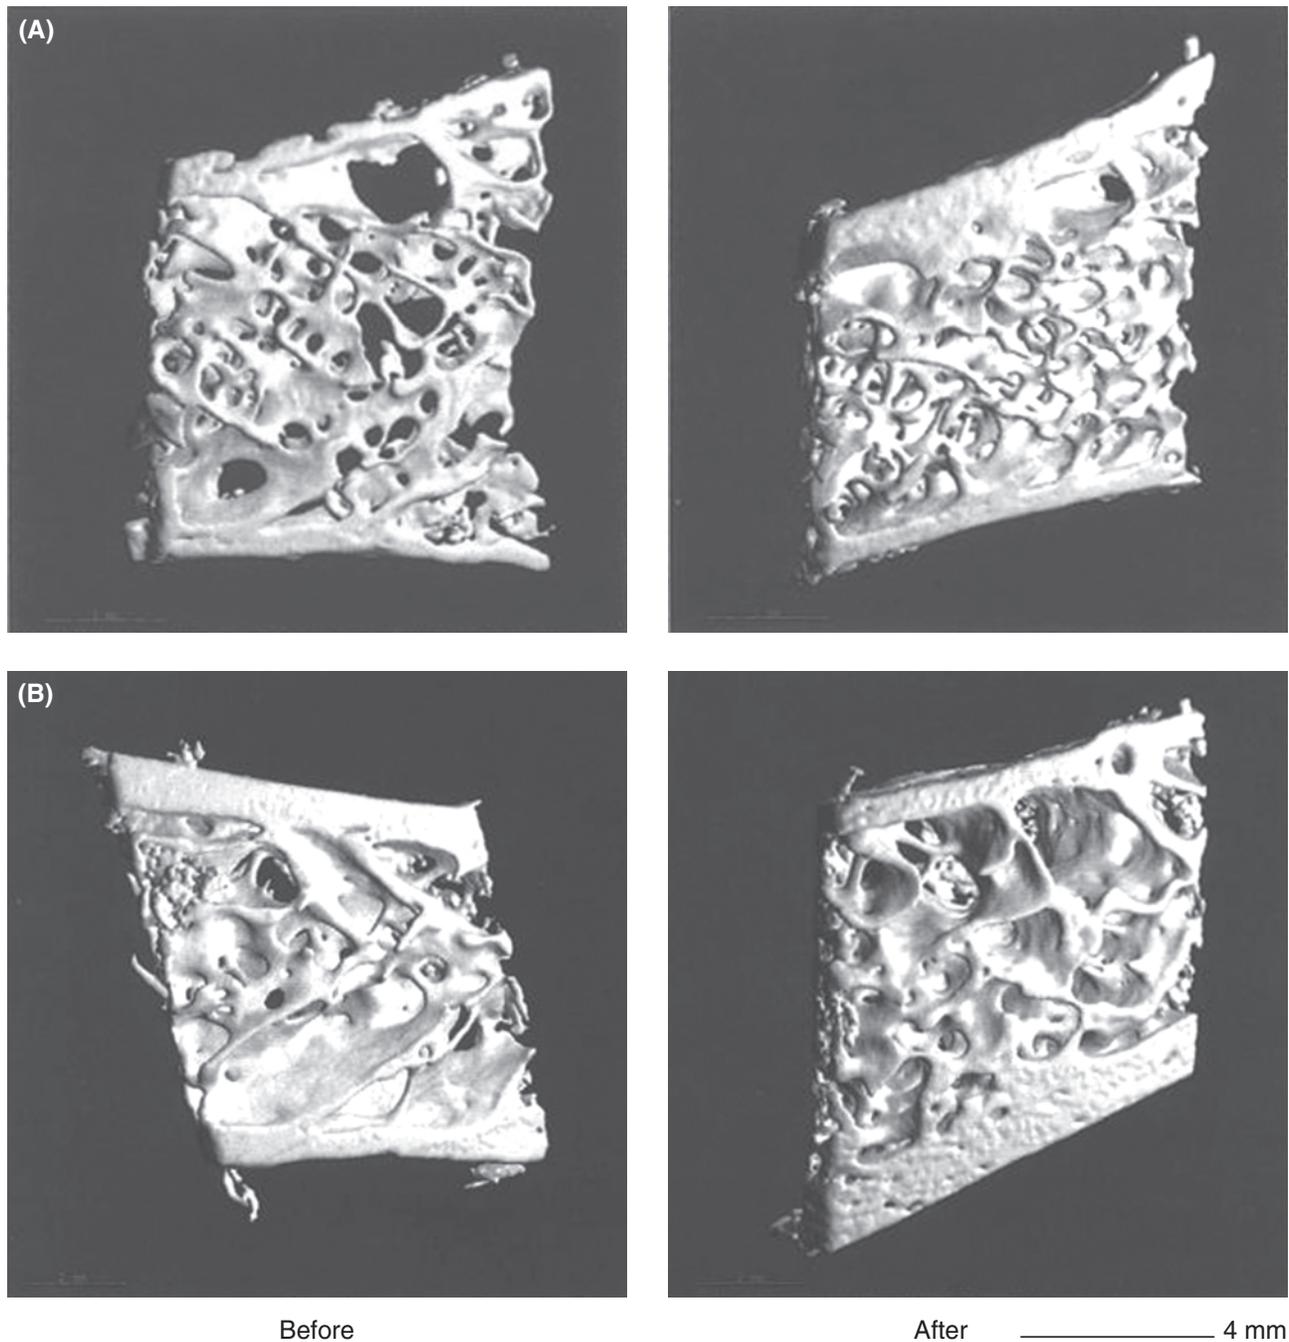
Microcomputed tomographic images of paired biopsies before (*left*) and after (*right*) treatment with PTH(1–34) in a 64-year-old woman (A) and a 47-year-old man (B). Note improvement in cancellous and cortical bone structure after treatment. Reproduced with permission from Dempster *et al.* (2001).
